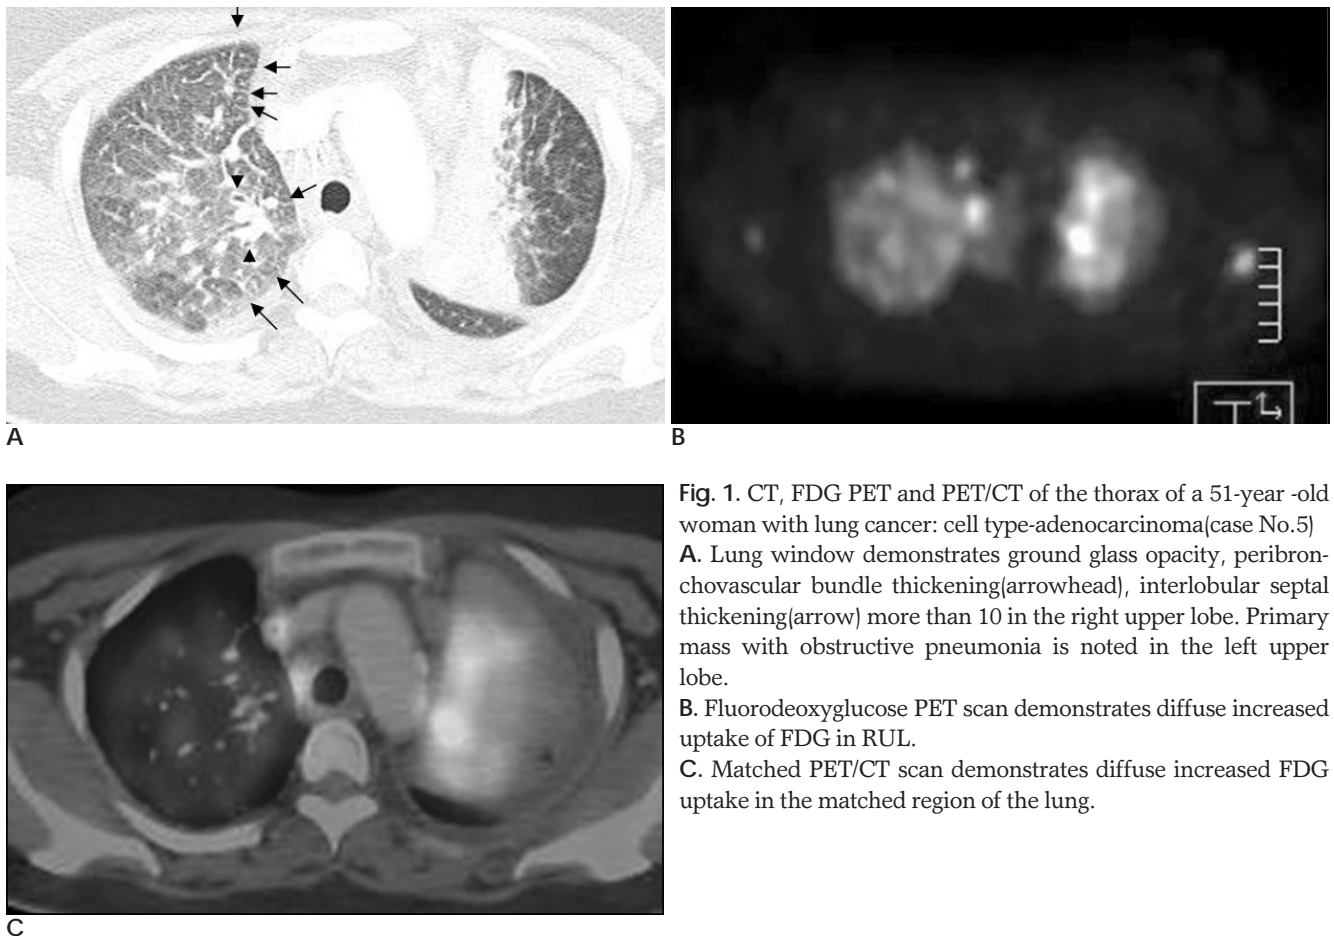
CT, FDG PET and PET/CT of the thorax of a 51-year-old woman with lung cancer: cell type-adenocarcinoma(case No.5)
